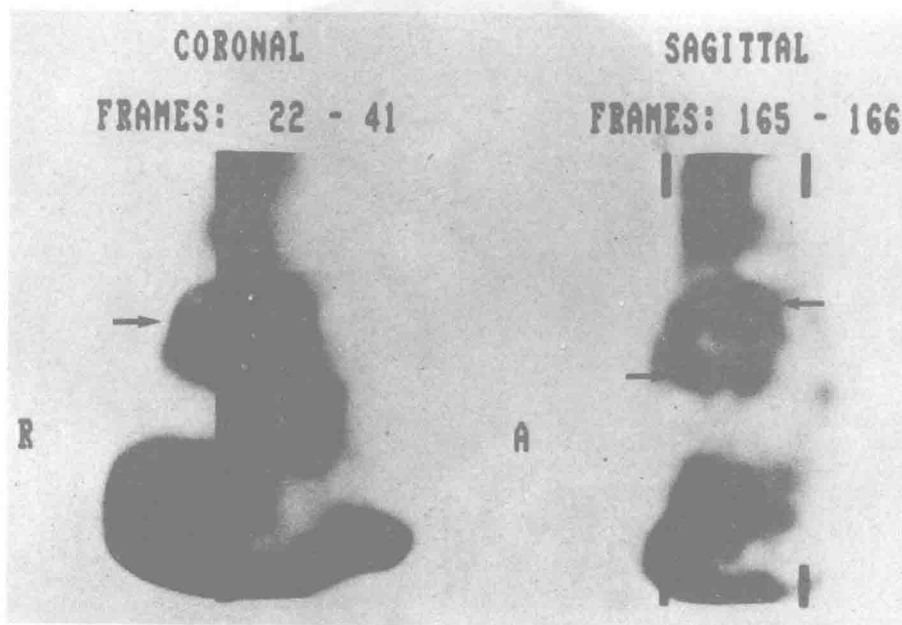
^{111}In .155H.7; SPECT: Uptake in metastasis to mediastinum.
